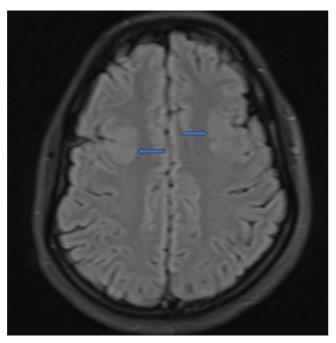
FLAIR axial MRI image showing focal gyral thickening with a paucity of sulci in the bilateral frontal cortices, suggestive of focal pachygyria (blue arrows)
